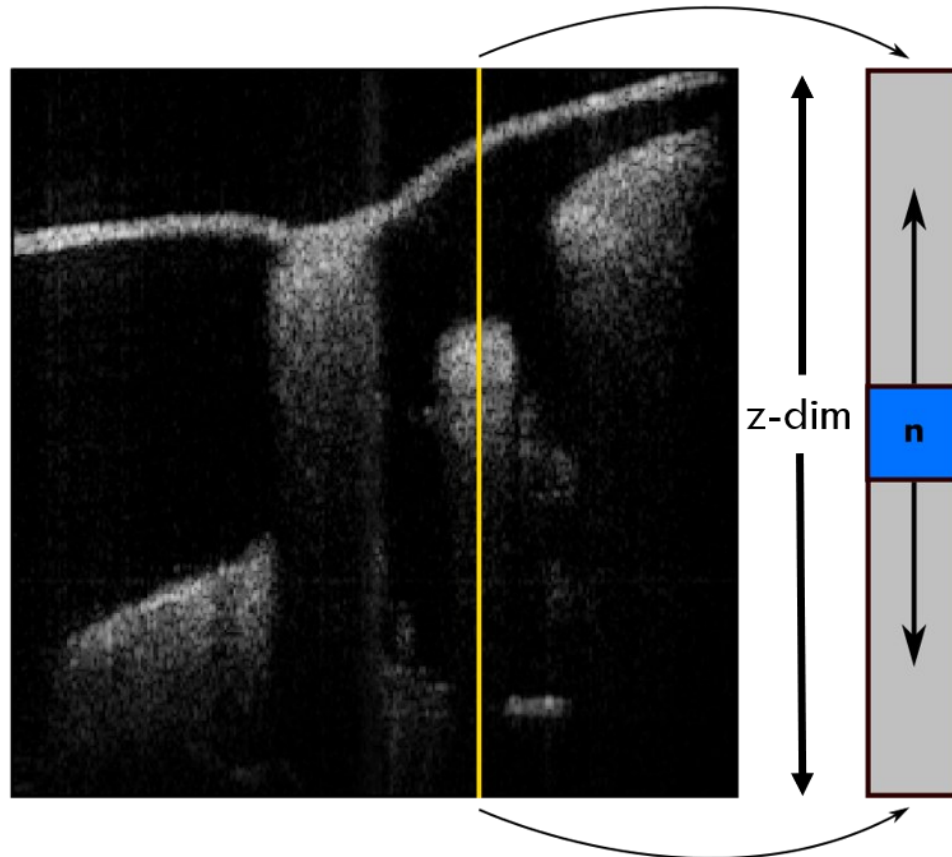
Doppler animation where a new position is calculated for every sample position n along the depth dimension z within each image line based on the Doppler vibrometry dataset.
